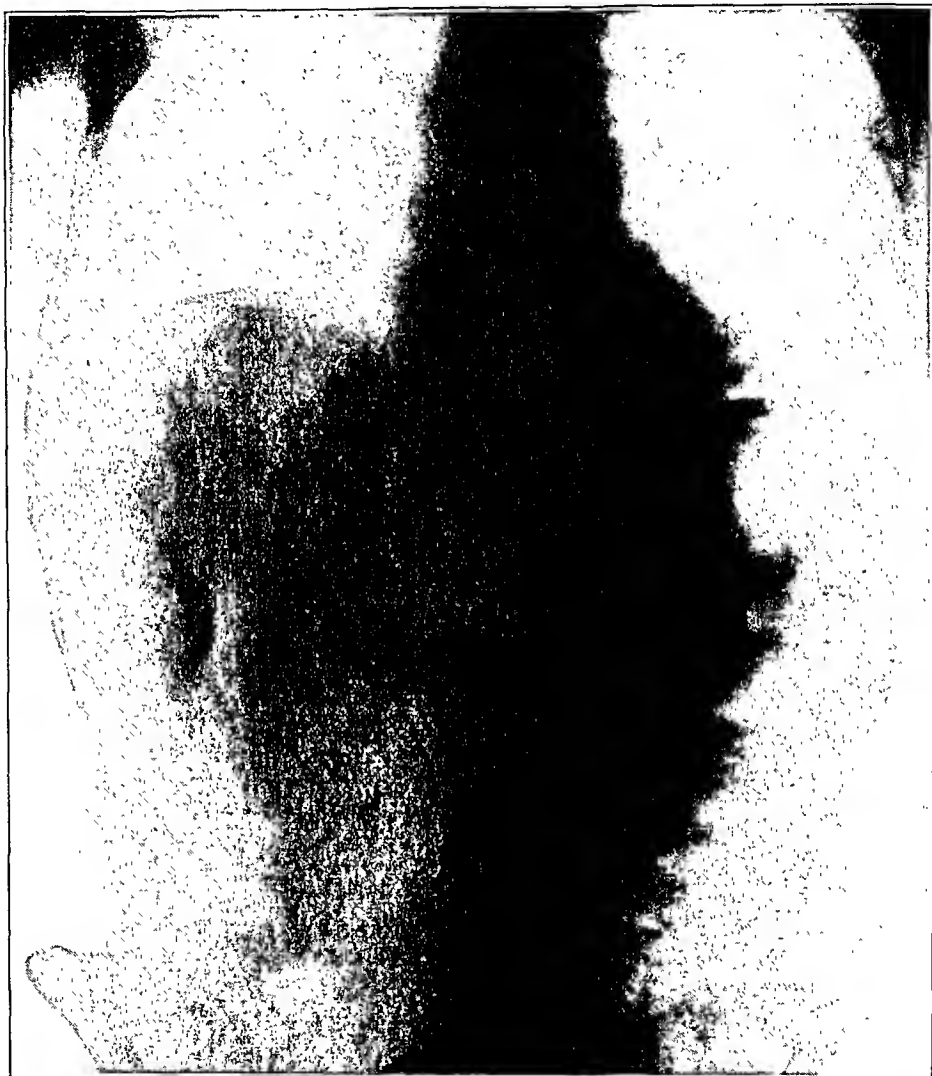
(case 14).—Roentgenogram taken four days after figure 3 and eleven days after perforation. The free air has been completely absorbed.
